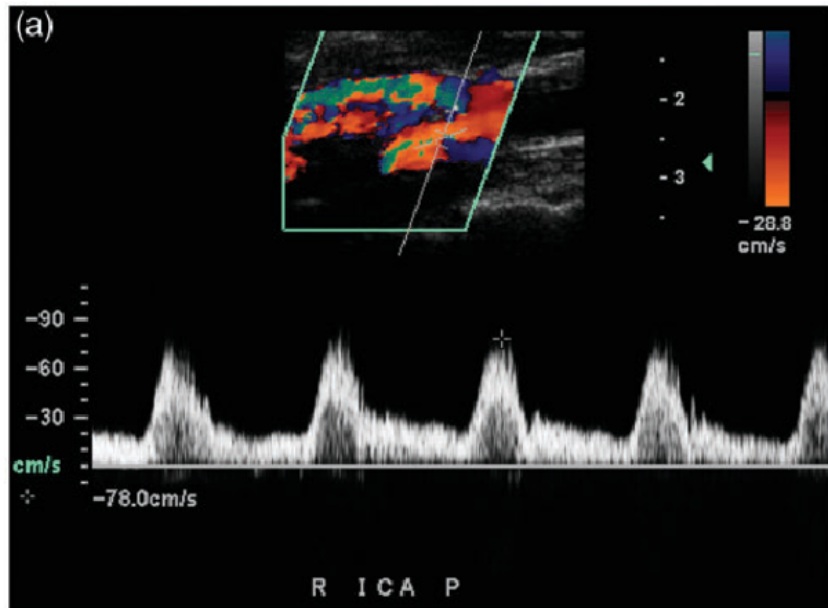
Tardus parvus refers to a pattern of Doppler ultrasound spectral waveform resulting from arterial stenosis. The phenomenon is observed downstream to the site of stenosis and is due to reduced magnitude of blood flow through the narrowed vessel during ventricular systole ⁴.
